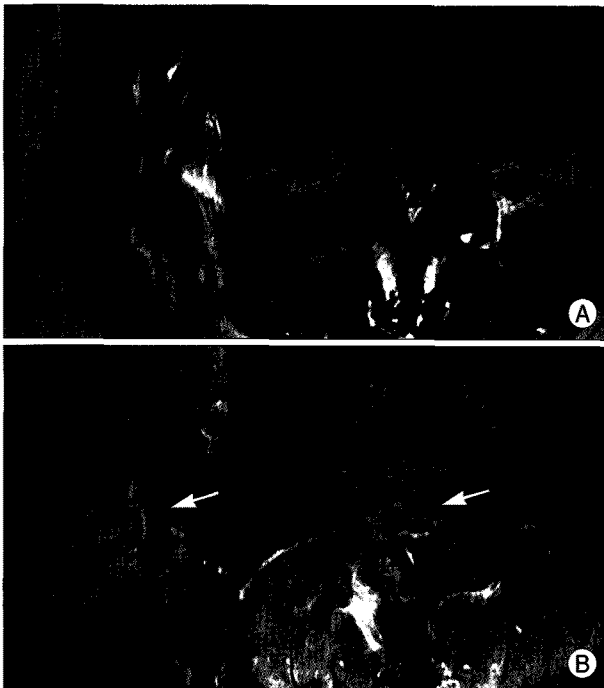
A 37-year-old male patient (patient 6) had a 2-week history of severe right buttock and leg pain. T1- and T2-weighted MRI 7 days after PELD revealing a lesion with low signal intensity and mild endplate erosions at the L4-5 level (A). Gadolinium-enhanced MRI 2 months after CT-guided aspiration biopsy showing a large epidural abscess (arrow) and more aggravated vertebral body destruction with spondylodiscitis (B). Coagulase negative *Staphylococcus* was identified from the infected disc.
